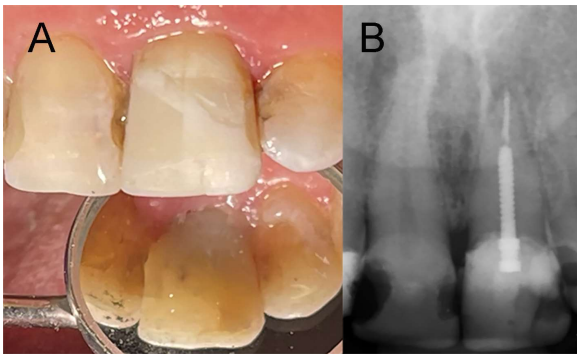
Clinical follow-ups and radiographic evaluation after adhesive reattachment: A) clinical follow-ups with the patient expressing satisfaction regarding treatment. B) Radiographic evaluation after one year demonstrating successful results.
